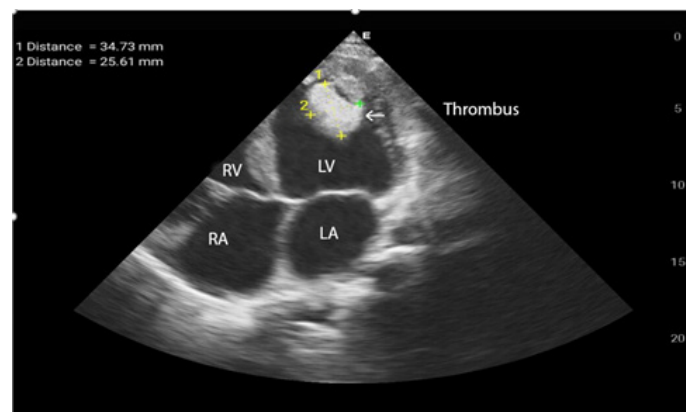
Two-dimensional transthoracic echocardiography. Apical view of the four chambers. Dilated left ventricle, containing a fixed apical thrombus.
